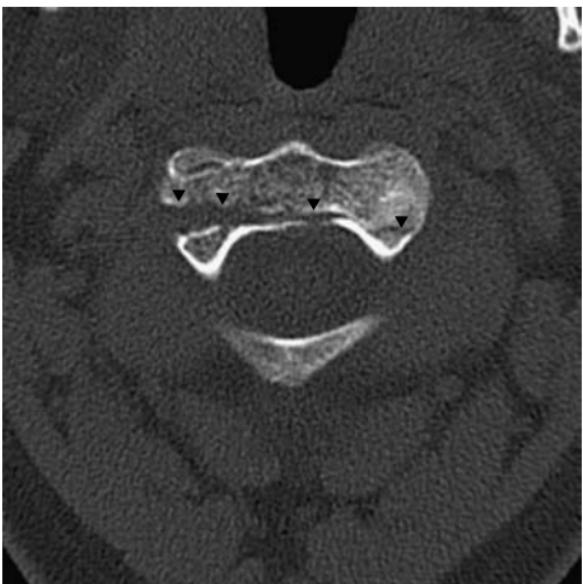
Coronal fracture of body of C2 Hangman's fracture. (a) CT sagittal MPR; (b): axial CT. Slightly displaced fracture through the body of C2 in the coronal plane ((a) white arrowheads; (b) black arrowheads). There is slight anterior subluxation of C2 upon C3.
